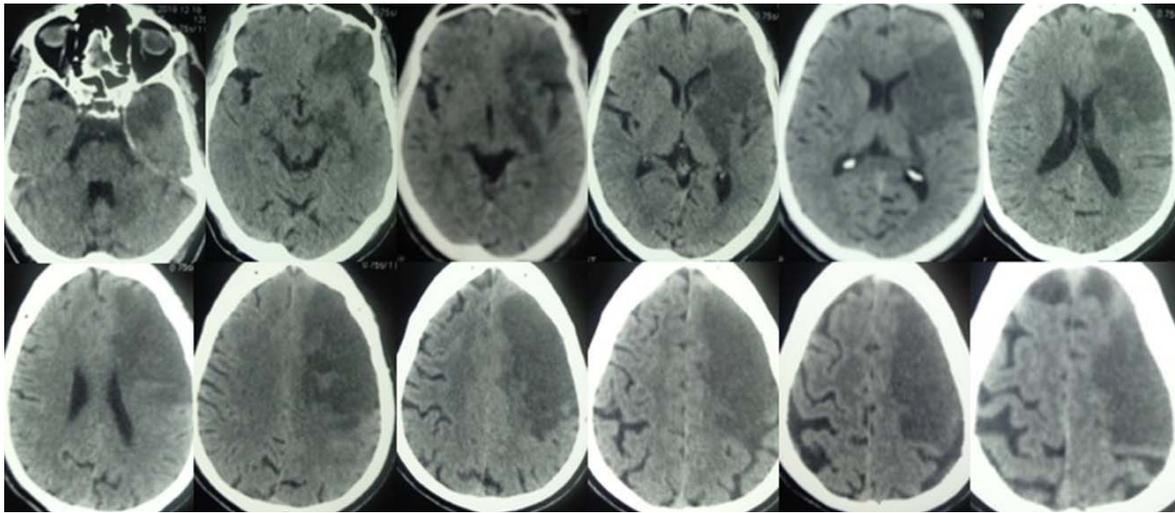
Non-contrast computed tomography at 44 hours following the bee stings showing spreading of the infarction in left cerebrum.
